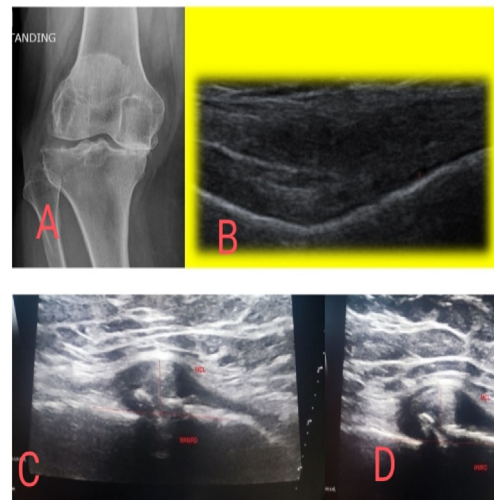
Male patient 70 years old complaining of pain and stiffness at the medial aspect of the right knee. (A) Lt knee radiograph AP view KL grade 4 (osteoarthritis) with large osteophytes, (B) US of medial compartment in supine position with flexed knee, cartilage thickness of medial femoral condyle = 0.6 mm. (C) US of medial compartment supine position NW-MRD = 10.3 mm. (D) US of medial compartment (standing) W-MRD = 11.2 mm.
